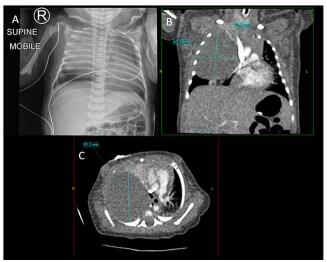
(A) Chest X-ray of Case 2 on Day 1 of life showing a homogenous opacification of the right middle and upper zones. (B) Coronal view of CT chest with a contrast of Case 2 on Day 2 of life showing a large low-density lesion in the right upper hemithorax which was not typical of CPAM and suggestive of a congenital lung tumor (C) Axial view.
